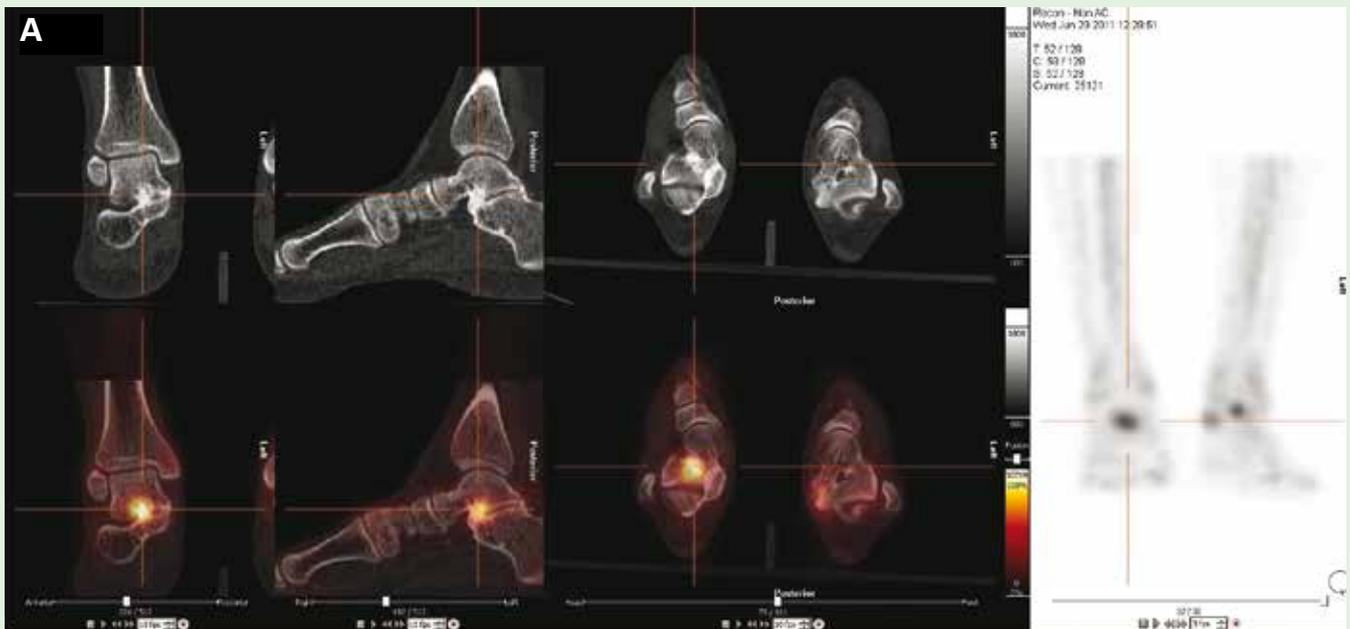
Bone scan with SPECT/CT (A) and planar images (B) of patient nr 1 showing uptake in the subtalar joint.
